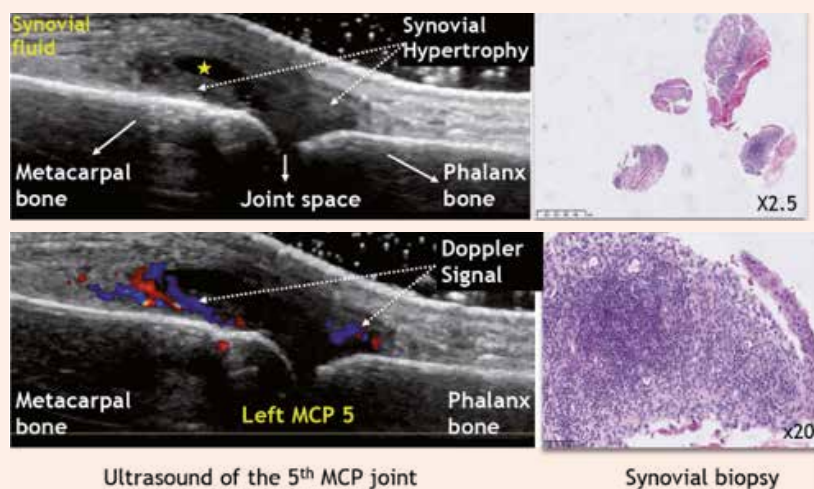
Ultrasound-guided synovial biopsies deliver material for a better stratification of RA patients based on the identification of specific molecular profiles in the tissue.
